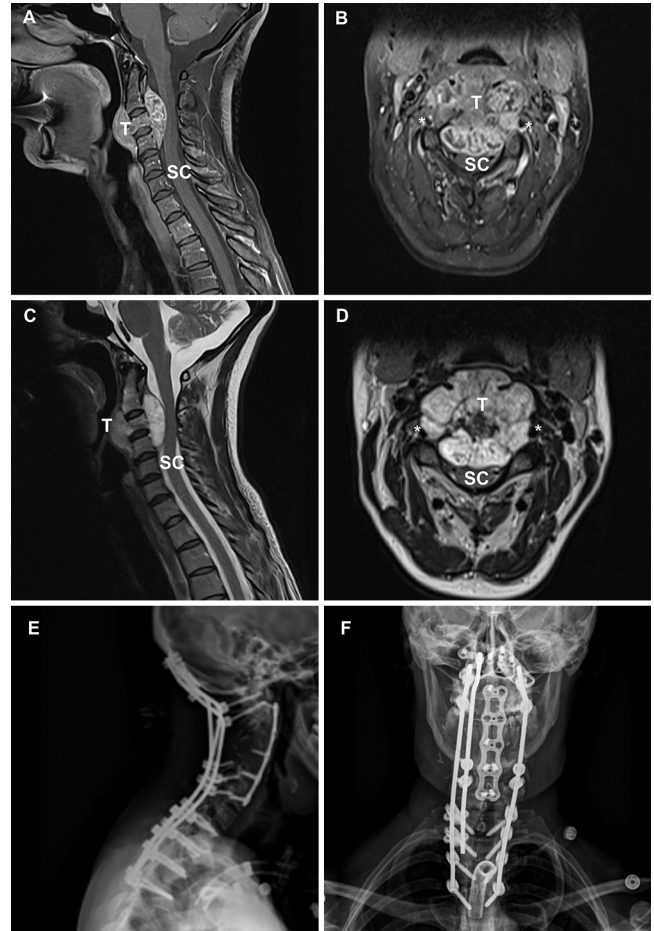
Preoperative sagittal T1-weighted (A), axial T2-weighted (B), sagittal T1-weighted (C), and axial T2-weighted (D) MRI sequences of a C3 chordoma. Postoperative radiographs, lateral (E) and anteroposterior (F) views, of the construct from occiput to T2 anterior and posterior EBR, instrumentation, and fusion. Asterisk indicates the vertebral artery. SC = spinal cord; T = tumor origin from C4.
